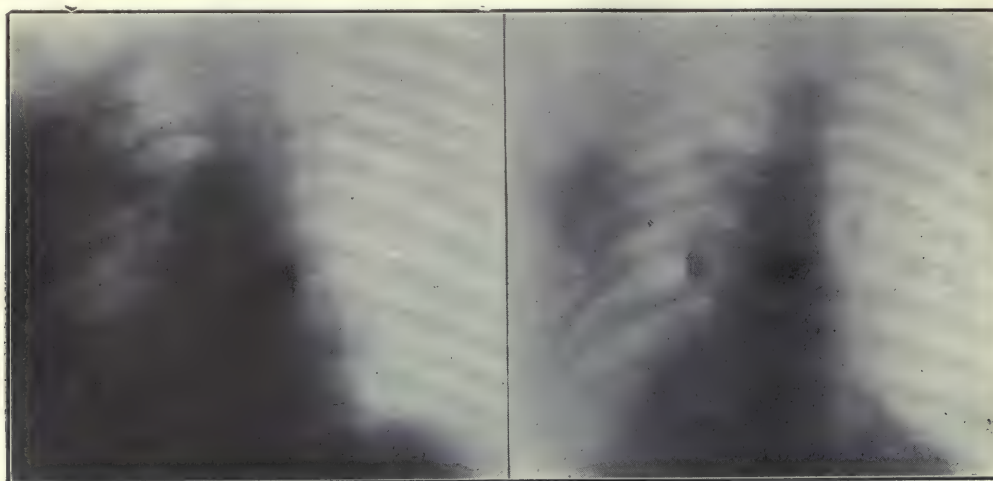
Stereoscopic radiographs of a bullet in the lung. Note the relations of the shadows of the bullet, and of the metallic "markers" placed, respectively, on the sternum and on the spine.
